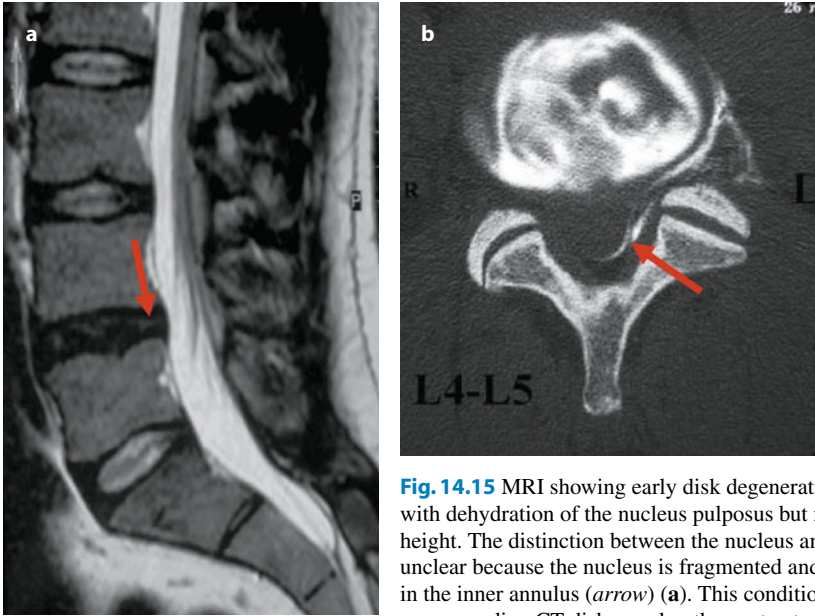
MRI showing early disk degeneration (Pfirrmann grade 3) with dehydration of the nucleus pulposus but minimal reduction of disk height. The distinction between the nucleus and annulus fibrosus is unclear because the nucleus is fragmented and “creeps” through tears in the inner annulus (*arrow*) (a). This condition is confirmed in b by the corresponding CT diskography: the contrast medium does not remain (as it should in normal anatomy) centrally confined to the nucleus but diffuses in a circumferential annulography. Tiny tears in the external annulus are also present, justifying the epidural leak (*arrow*)
